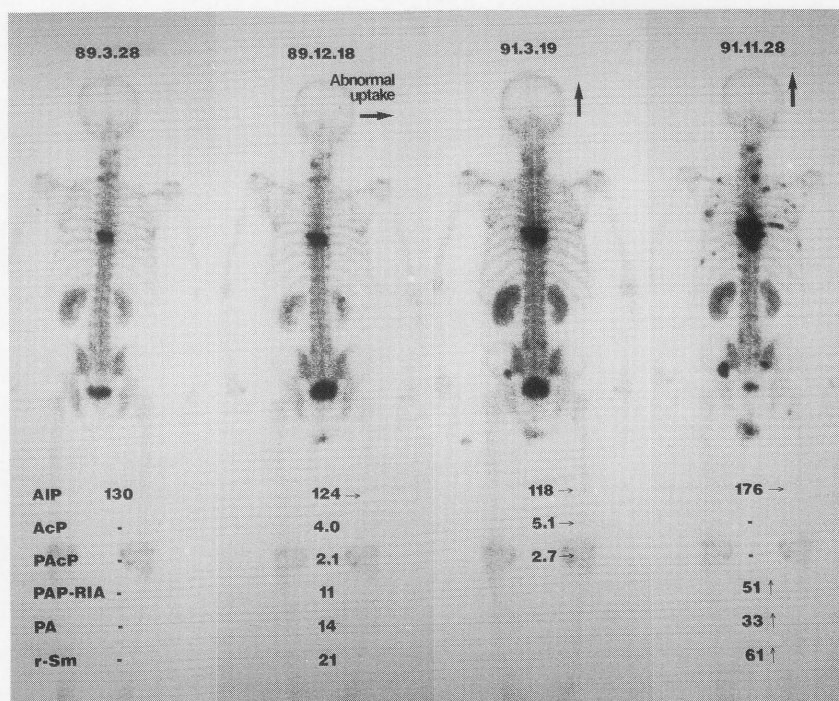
A 73-year-old patient with temporary good response, but continuous deterioration afterward. Changes in the scintigraphic findings and tumor markers were in good agreement.
